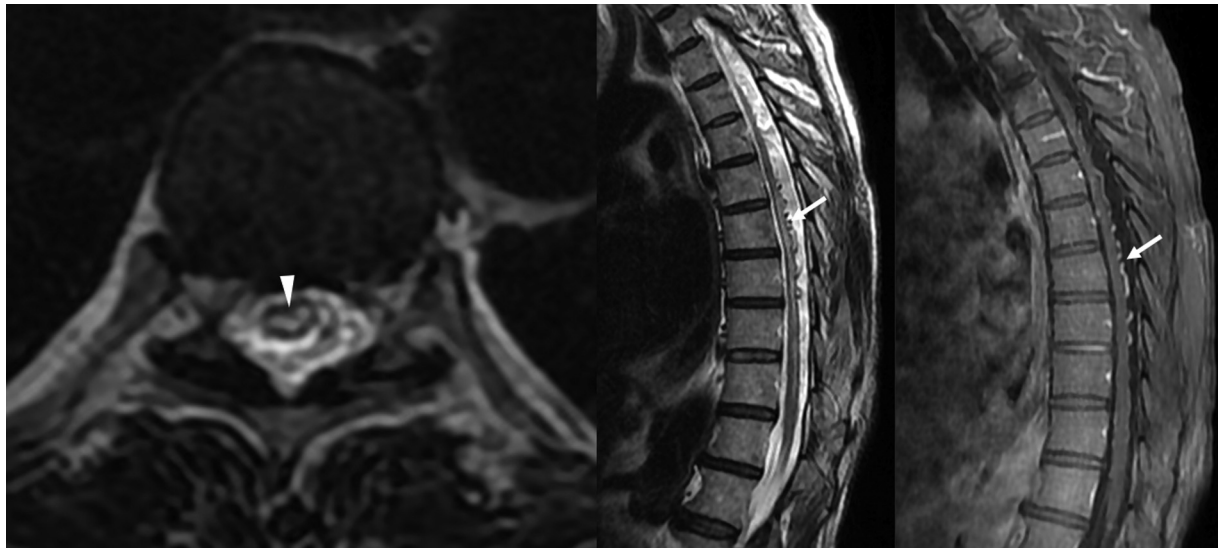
Magnetic resonance imaging (MRI) scans of the thoracic spine: T2-weighted axial (A) and sagittal (B) images showing centromedullary edema (arrow) and prominent serpiginous intradural extramedullary flow voids (arrow); And T1-weighted sagittal postcontrast image (C) depicting enhancement of these vessels (arrow).
